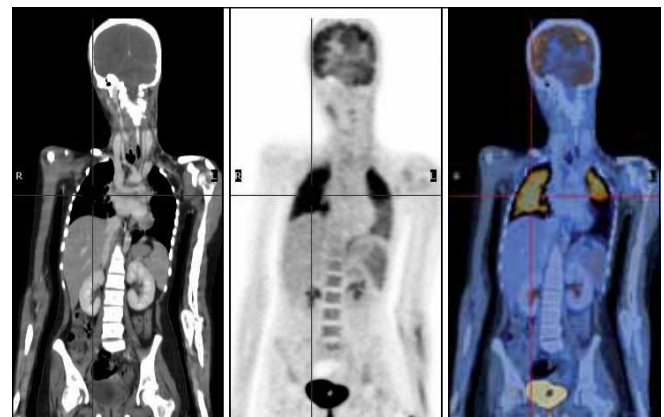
FDG PET-CT coronal images showing uptake in the lungs
